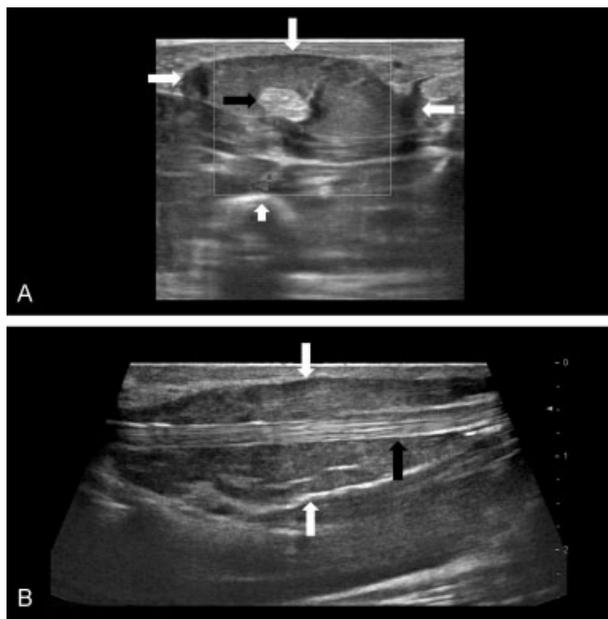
Axial (A) and sagittal (B) sonographic images of the right index finger showing a hypoechoic solid mass lesion (long white arrows) surrounding the FDP tendon (black arrows). The FDS tendon is notably absent. The short white arrow indicates the second metacarpal.
